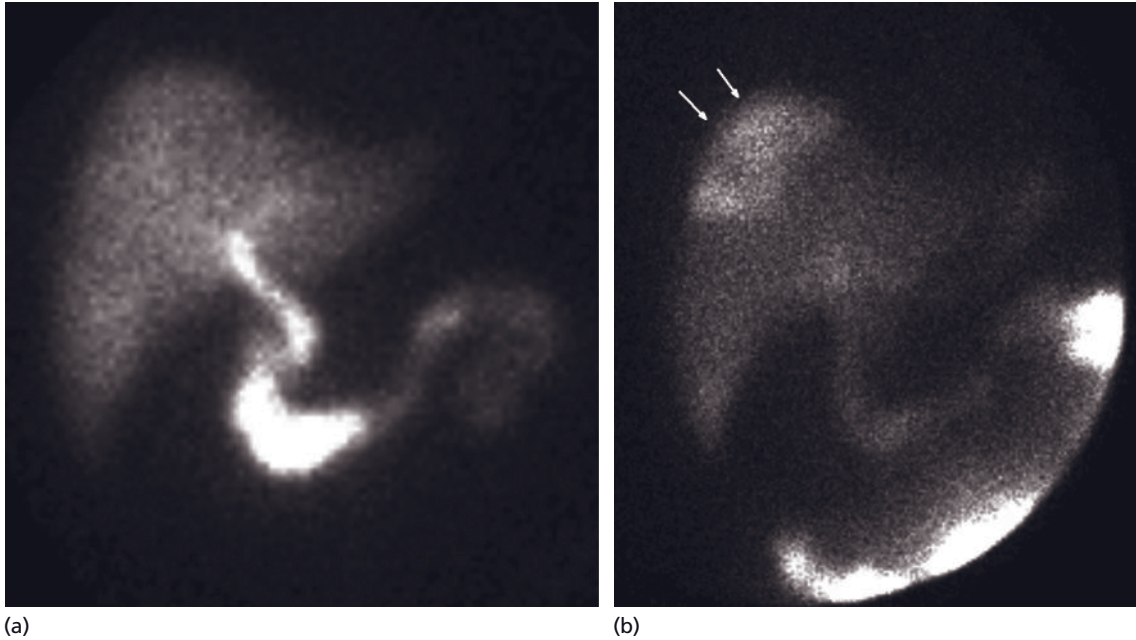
(a) Technetium-99m hepatobiliary iminodiacetic acid cholescintigraphy (HIDA) scan demonstrating prompt biliary tracer excretion. (b) Delayed images confirm the presence of a bile leak with a biloma at the dome of the liver (arrows).
